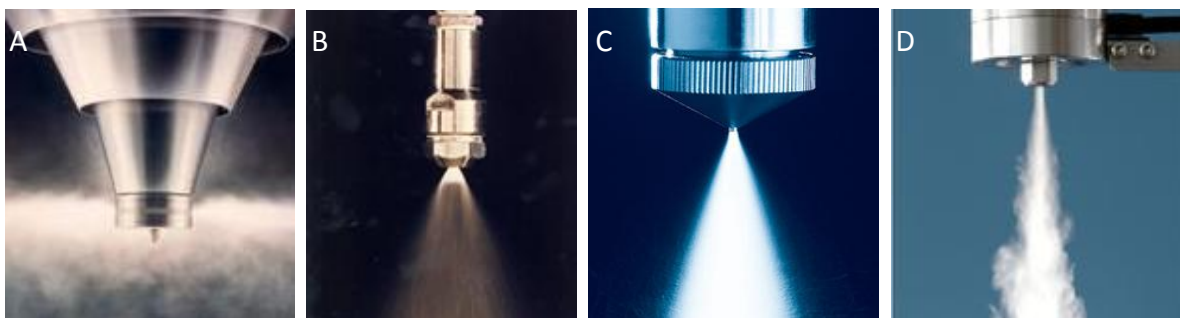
Atomization devices: A: rotary atomizer, B: pressure nozzle, C: pneumatic nozzle, D: ultrasonic nozzle
